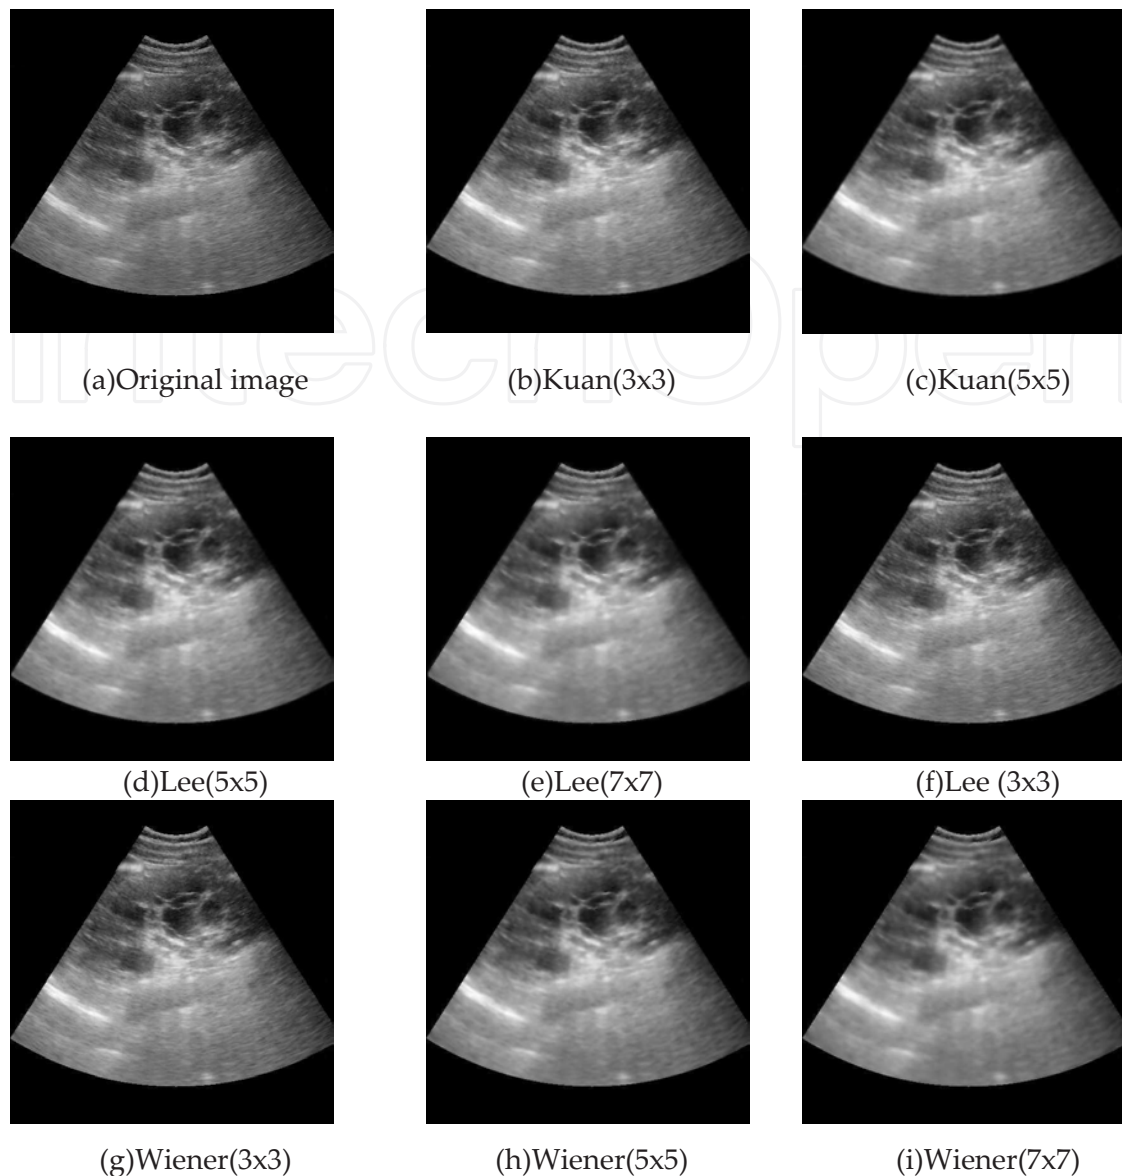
Performance comparison of various despeckling filters by visual inspection of an ultrasound image of kidney.
